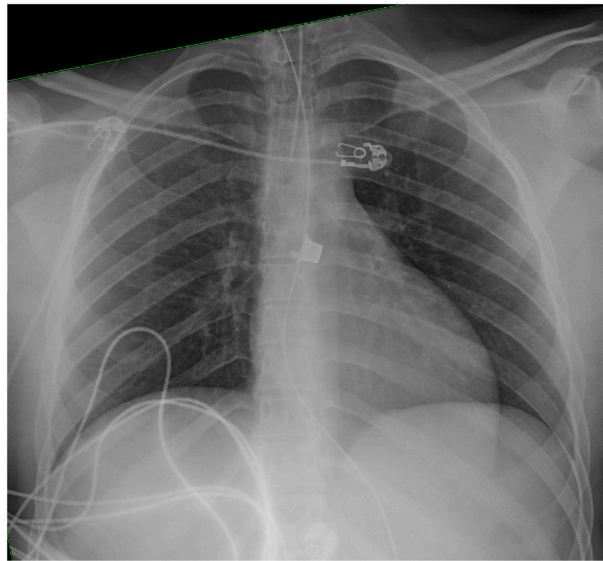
Chest X-ray showing bullet fragment projecting over the mediastinum and no hemothorax or pneumothorax.
